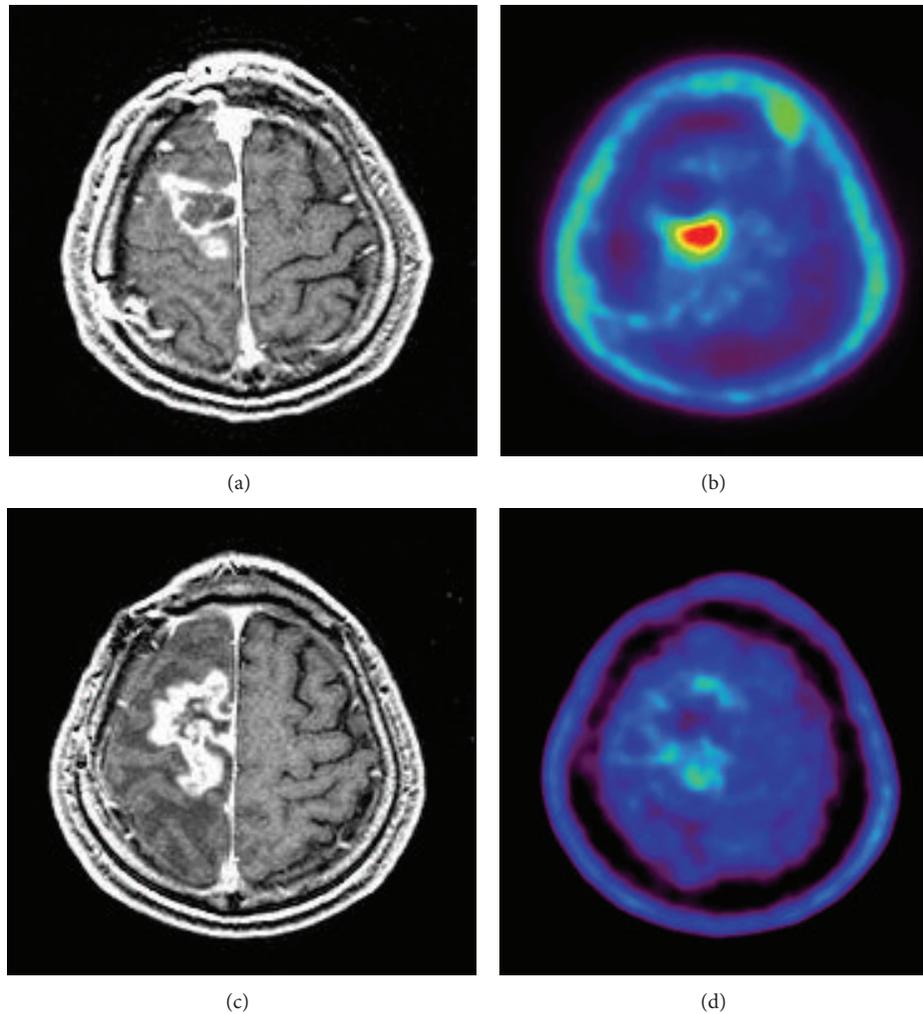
A 56-year-old man of GBM with symptomatic radiation necrosis. Before Hypo-IMRT, enhanced lesions were demonstrated in the right frontal lobe on T1-weighted magnetic resonance imaging (MRI) (a). ^{11}C -Methionine positron emission tomography (MET-PET) demonstrated a MET high-uptake on the region (b). 12 months after Hypo-IMRT, the enhanced lesion with perifocal edema was increased in size (c), although MET uptake decreased in the irradiated region (d). Second surgery was performed, and pathological diagnosis was defined as necrotic tissue without viable tumor cells.
